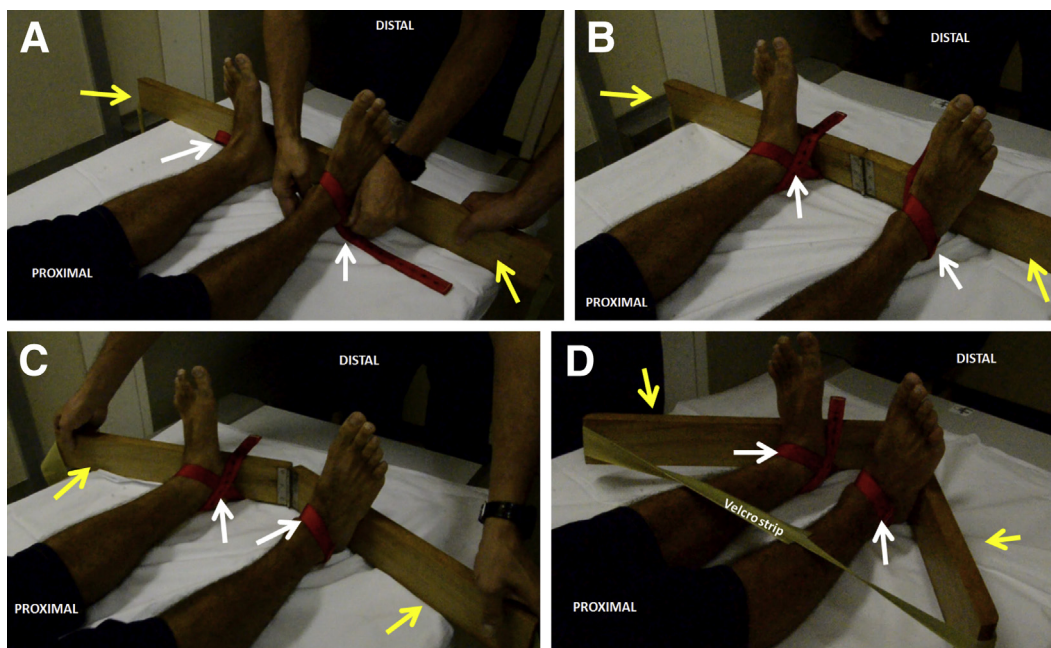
Eversion stress radiographs technique performed simultaneously in both limbs. A wooden hinge device (yellow arrows) is used to secure both limbs in neutral position. The straps (white arrows) are placed around the ankle (A), at the joint-line level, and secured in the device (B). Following this, the physician pushes both extremities of the device proximally, and consequently an eversion stress is applied in both ankles (C). A Velcro strip is then used to secure the hinge device in position, avoiding the need of a physician inside the radiographic room during the acquisition of the radiographs (D).
